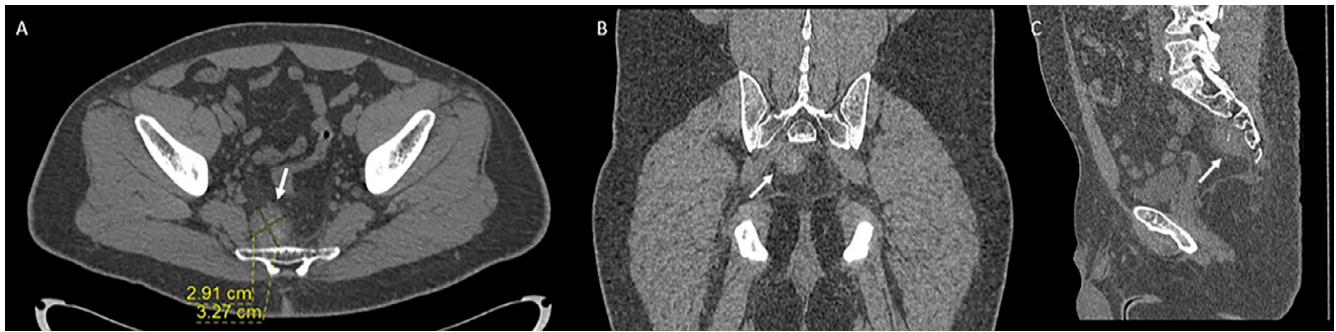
Computed tomography depicting a solitary mass (arrow) on the right anterior aspect of the sacrum. (A) Axial image, (B) Coronal image, (C) Sagittal image.
